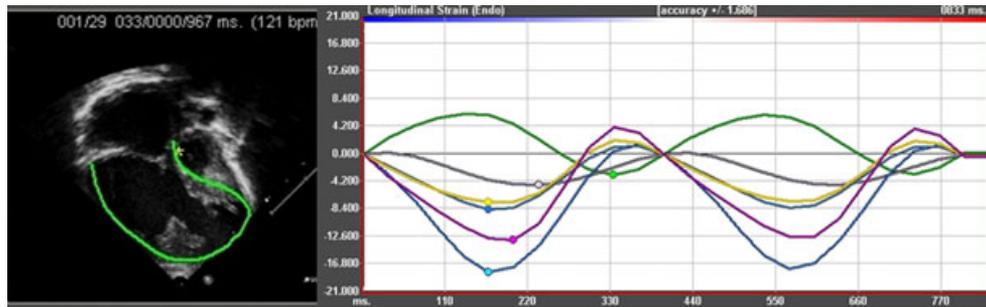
Longitudinal strain curves taken over 2 beats in a patient with hypoplastic left heart syndrome post Norwood operation. These strain curves were obtained from an apical four chamber stored as digital imaging and communications in medicine format and following manual tracing of the endocardial border processed using vendor-independent software (Image arena; TomTec imaging systems, Munich, Germany). There is marked heterogeneity in systolic function with the basal septal segment (in green) being stretched represented by a positive curve during systole and varying time to peak systolic strain in the other segments.
